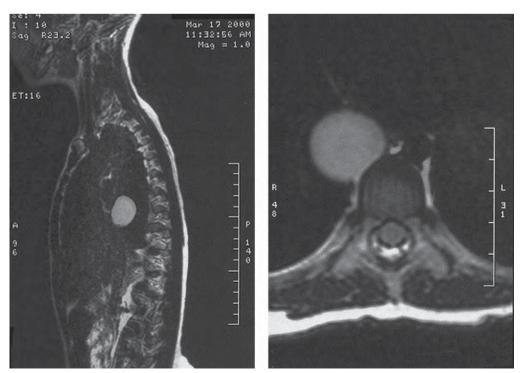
A 6-year-old girl had been operated on and followed since birth for a low lumbar lipomeningocele. An asymptomatic foregut duplication cyst was incidentally detected on these T2-weighted magnetic resonance images done to evaluate for a tethered cord (A, sagittal view; B, axial view). She underwent an uncomplicated thoracoscopic resection. (From Laberge J-M, Puligandla P, Flageole H: Asymptomatic congenital lung malformations. Semin Pediatr Surg 14:16-33, 2005.)
